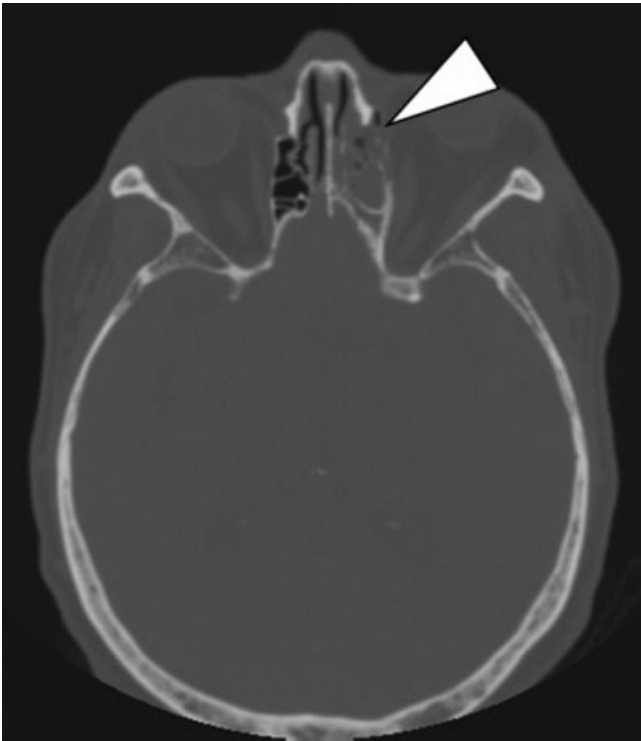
Noncontrast axial computed tomography scan demonstrating significant opacification of the left ethmoid. An area of dehiscence of the left lamina papyracea (arrowhead) and associated periorbital inflammation are seen.
